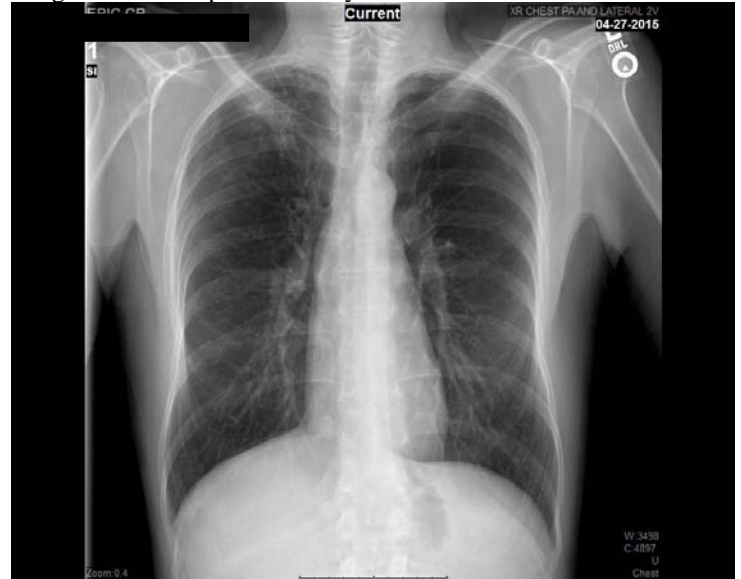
Follow-up Chest X-ray.
